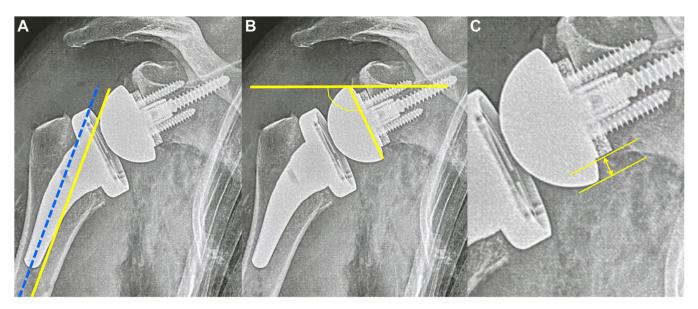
Postoperative X-rays analysis. (A). Stem axis (*blue line*) and humeral axis (*yellow line*). (B). Levigne angle (value >90° = inferior tilt). (C). Inferior offset defining the height of the glenoid implant: high (negative offset), flush (null offset), or low (positive offset).
